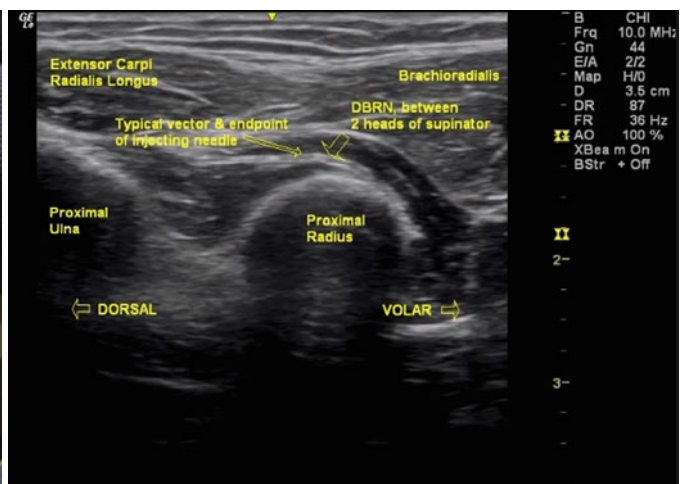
Ultrasound-guided injection of deep branch of radial nerve at the radial tunnel (Image courtesy of Richard Seroussi, MD)
